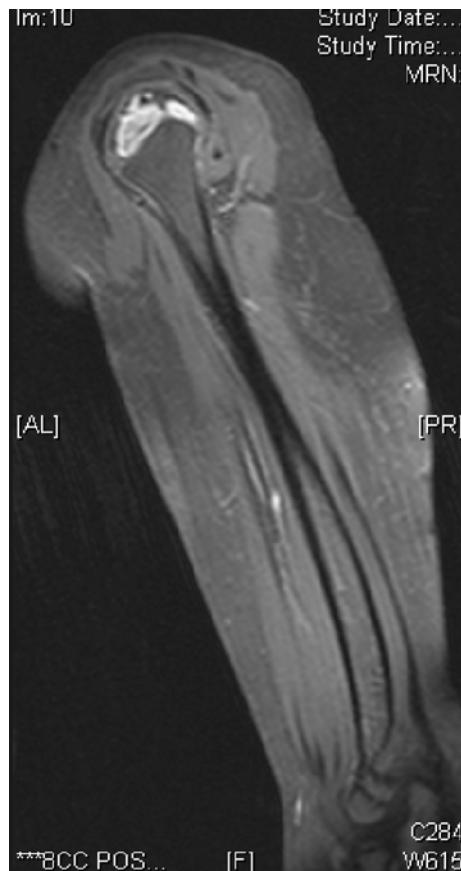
T2-weighted sagittal MR image, with fat suppression, showing hyperintense signal in that same epiphyseal lesion
